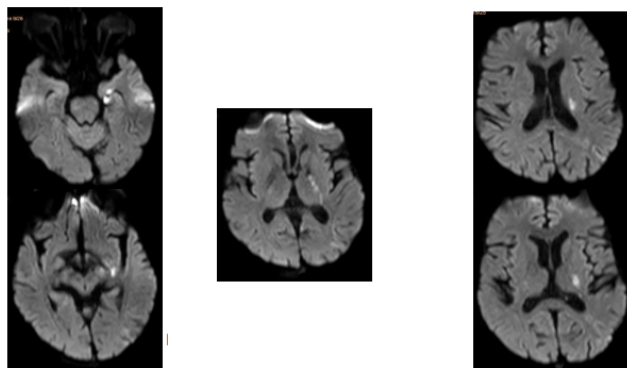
Final MRI (after the second event) revealing new infarcts at posterior limb of internal capsule, anterior temporal lobe and corona radiata.
